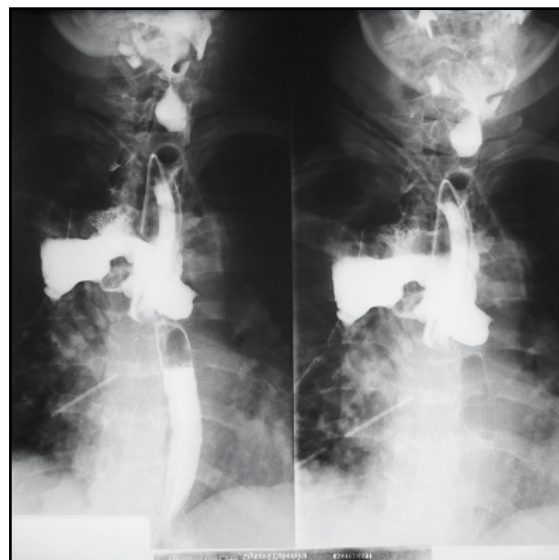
Contrast X-ray (oral route) 10 days after mediastinal drainage – persisting leak of contrast solution.
